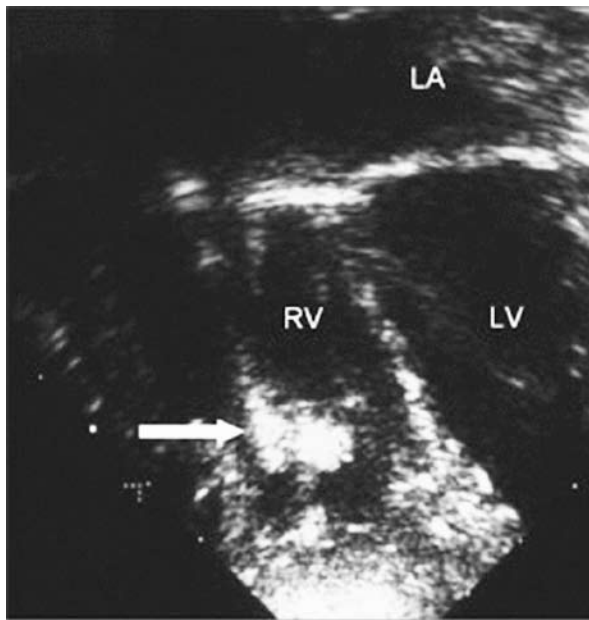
Transesophageal echocardiogram showing vegetations (arrow) attached to the leads. LA - left atrium, LV - left ventricle, RV - right ventricle
